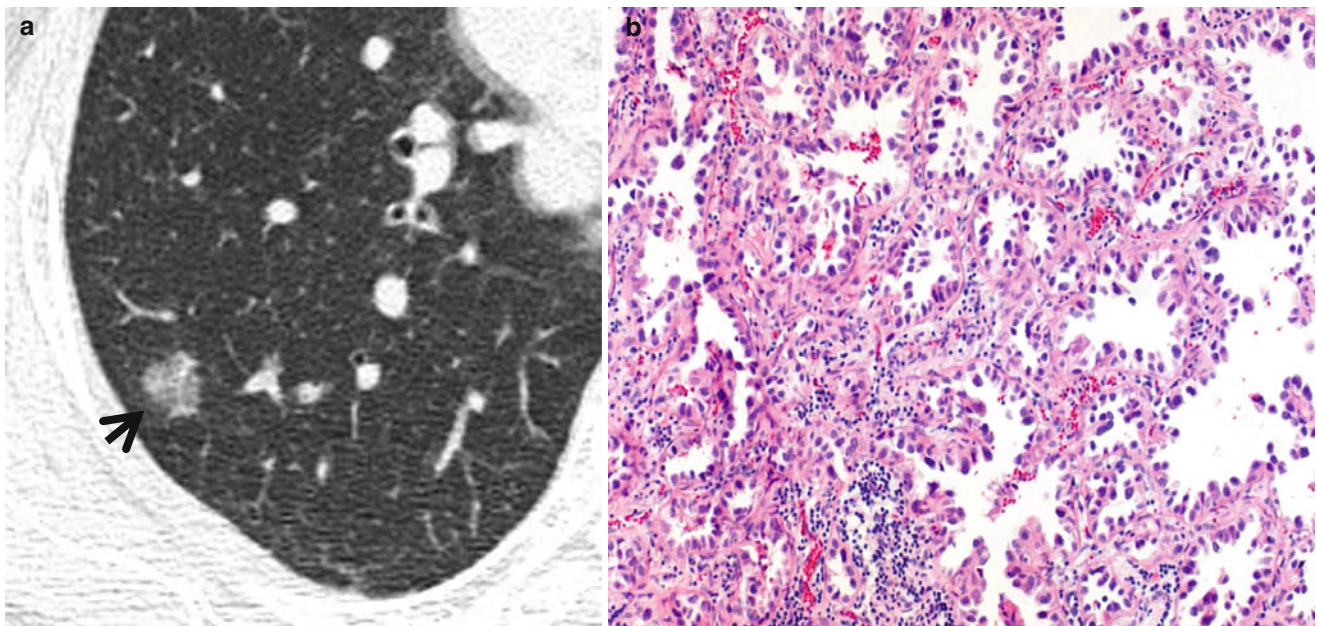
Pure ground-glass opacity nodule representing adenocarcinoma in situ (AIS, former bronchioloalveolar carcinoma) in a 45-year-old woman. (a) Targeted view of thin-section (1.5-mm section thickness) CT scan obtained at the basal segmental bronchi shows a 13-mm-sized
